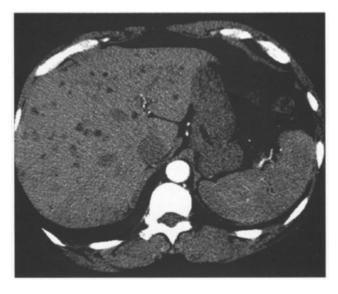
CT scan of multiple Von Meyenburg Complexes. They are presented as non enhancing hepatic low density lesions.
